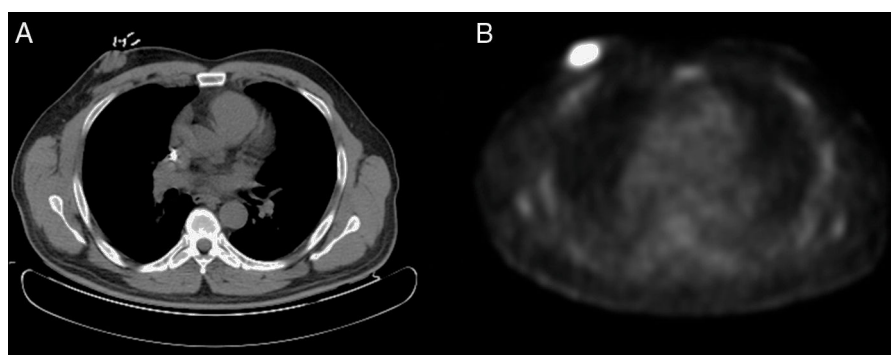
PET-CT: (A) computed tomography demonstrating a mass measuring 4×3.5 cm in the right breast; (B) positron-emission tomography showing evidence of a mass with hyperuptake in the right breast with an SUV_{max} of 12.
